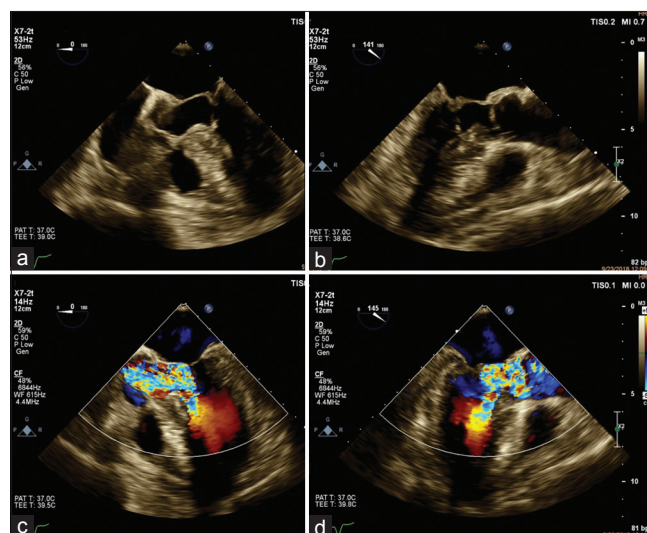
Systolic anterior motion of the mitral chordae tendineae (arrow) in transesophageal echocardiography [(a) mid-esophageal five-chamber view and (b) mid-esophageal long-axis view of the aortic valve], resulting in left ventricular outflow obstruction in color Doppler study [(c) mid-esophageal five-chamber view and (d) mid-esophageal long-axis view of the aortic valve]. LA, left atrium; LV, left ventricle; AO, ascending aorta
